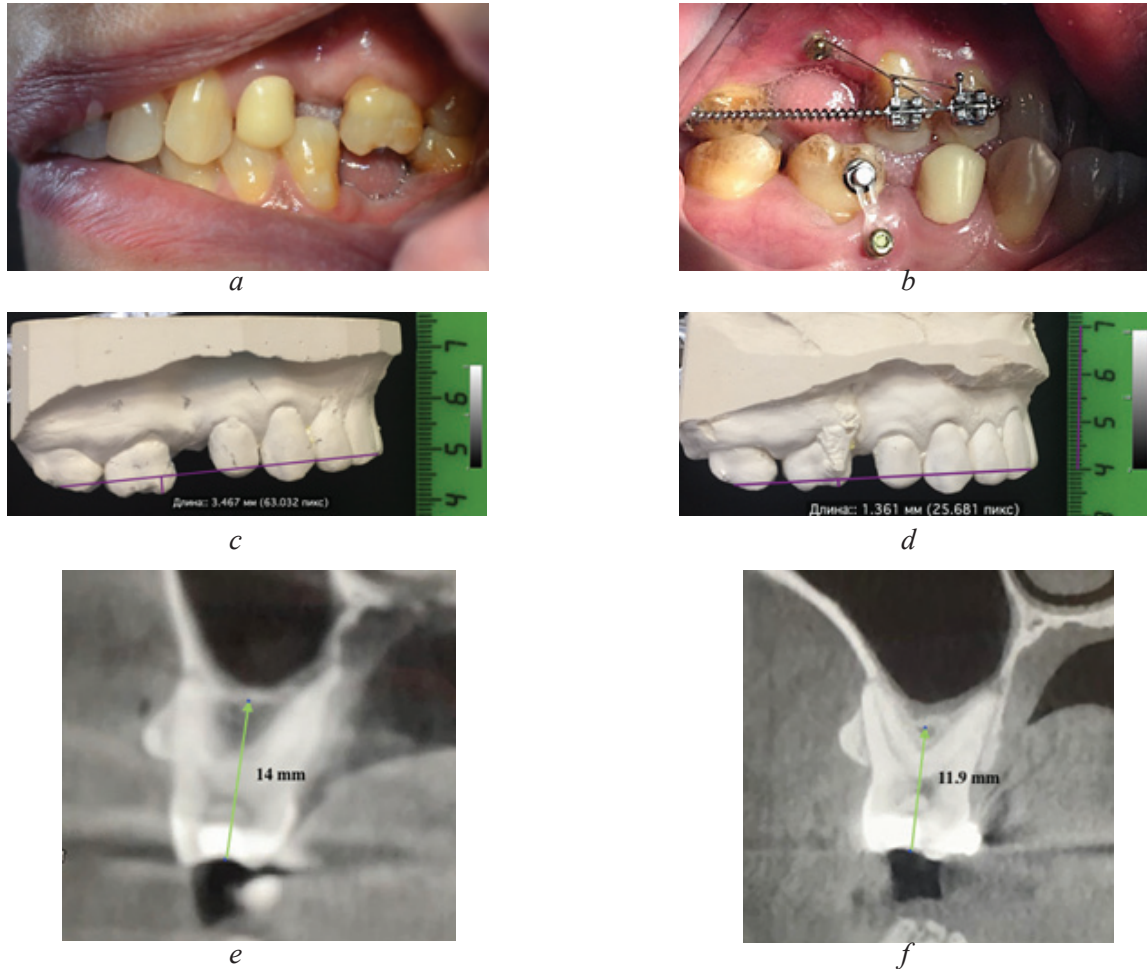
a, b* – intraoral photo, *c, d* - maxillary casts, *e, f* - CBCT sections in the area of the moved tooth 1.6 before and after intrusion. The treatment time was 5.5 months, the intrusion was 2.1 mm
